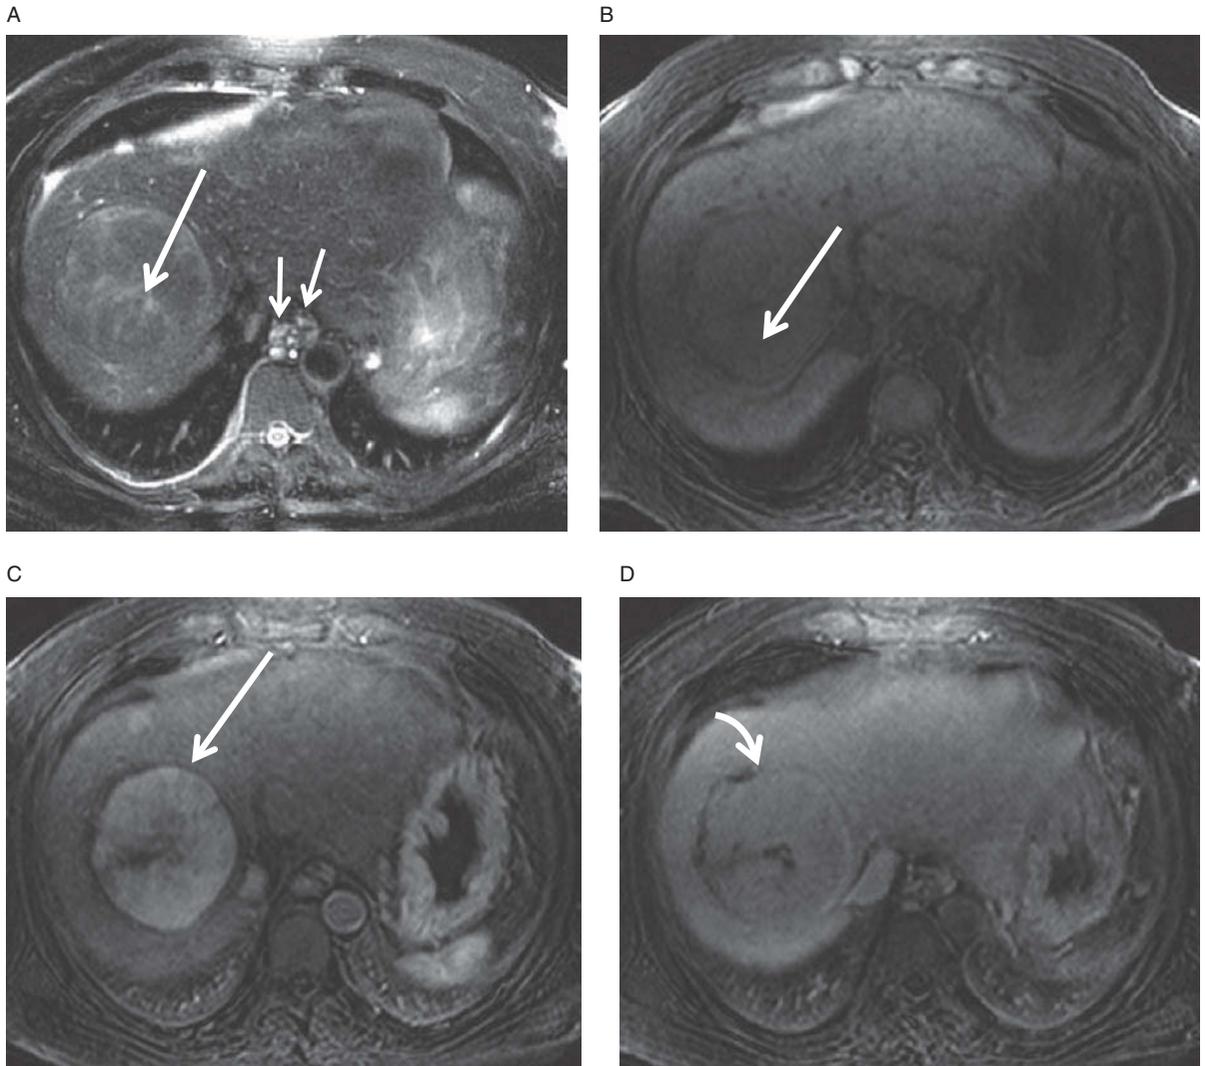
Well-encapsulated HCC. Axial T2-weighted image (A) shows mildly increased signal in a large hepatic mass (arrow). Axial, T1-weighted, fat-saturated pre-contrast image (B) shows nearly hypointense mass which demonstrates marked arterial-phase enhancement (C) and slight washout on delayed image (D). If you are thinking, wait a minute, couldn't this be an FNH with a central scar . . . look again. It's too heterogenous on T2. Also, notice the washout of the capsule on the delayed image (D) (curved arrow). Also, see T2-bright esophageal varices on image (double arrow) A. All of these features make this an HCC.
